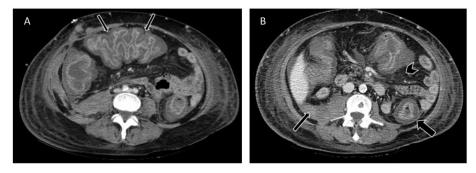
Image A. Accordion sign in a patient with confirmed *Clostridium difficile* infection in transverse colon (thin arrows). Image B. Abdomen CT scan of a patient with confirmed *Clostridium difficile* infection. Colonic wall thickness, target sign (*thick arrow*), peritoneal fluid (*thin arrow*) and pericolonic fat stranding (*arrowhead*) are shown.
